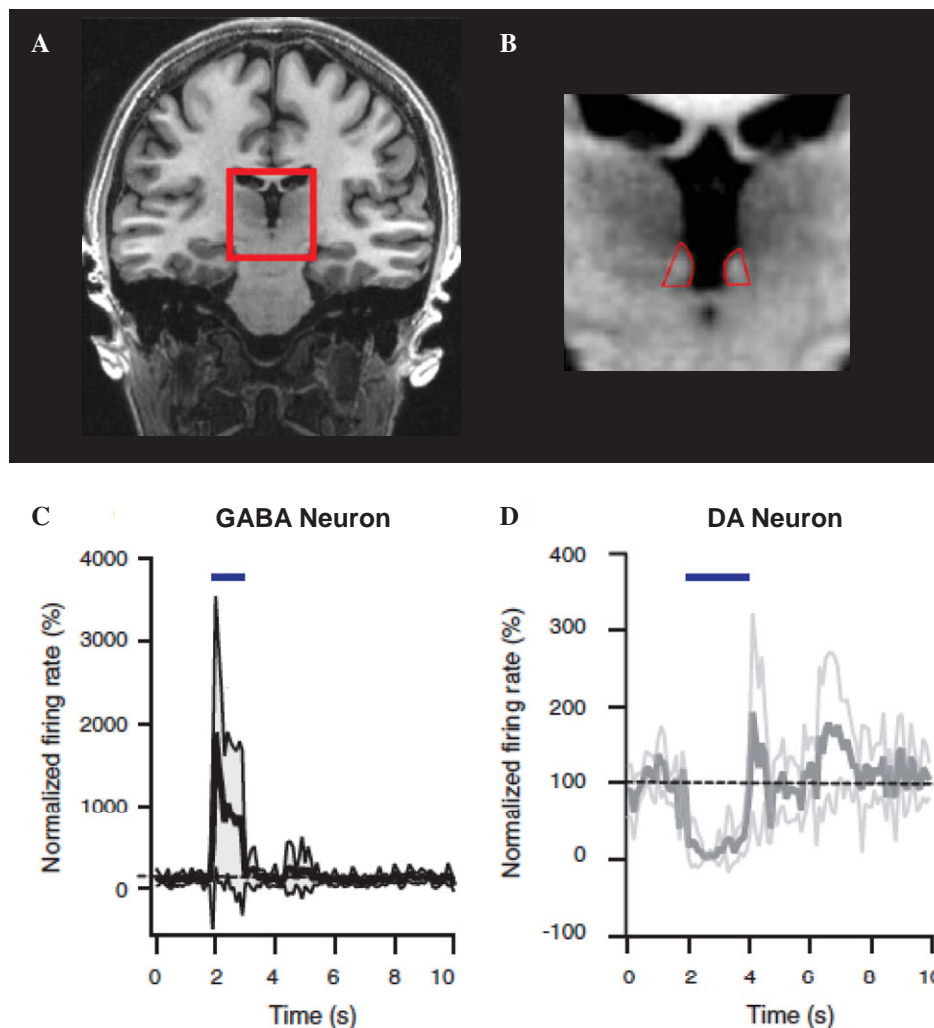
Activation of the habenula and VTA GABA neurons inhibits VTA dopamine neurons. (A) Red box highlights the habenula and neighboring structures in a coronal MRI image. (B) Closeup of the habenula. Images A and B reprinted from Lawson et al.,^[125] copyright 2013, with permission from Elsevier. (C) Optogenetic stimulation of VTA GABA neurons. The blue bar denotes the stimulation period, the trace depicts the normalized firing rate of eight neurons (mean, heavy black trace; *SD*, shaded gray area). (D) Optogenetic inhibition of VTA dopamine neurons during stimulation of VTA GABA neurons. The blue bar denotes the stimulation period, the trace depicts the normalized firing rate of 12 dopamine neurons (mean, heavy gray trace; *SD*, light gray trace). Images C and D reprinted from Tan et al.,^[134] copyright 2012, with permission from Elsevier.
